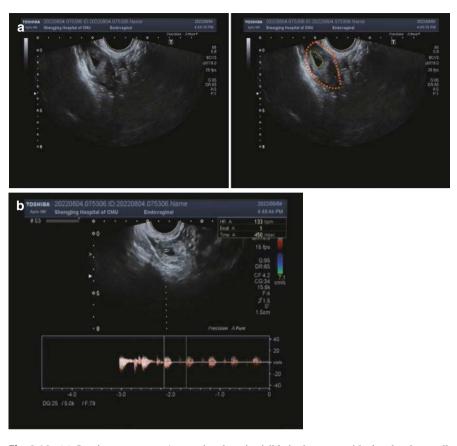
(a) Ovarian pregnancy: A gestational sac is visible in the ovary with clear borders, yolk sac, and embryonic structure. The ovary is circled in orange; the gestational sac is circled in green. (b) Ovarian pregnancy: Spectral Doppler detects fetal heartbeats within the embryonic structure
